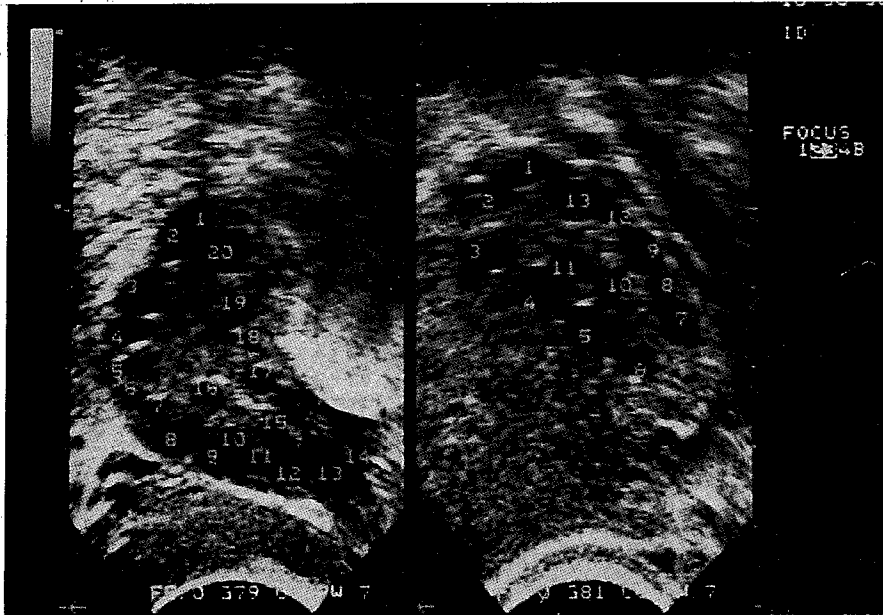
Picture PCOS diagnosed by ultrasound. Small, multiple and arranged cysts under the capsule of the ovary.
